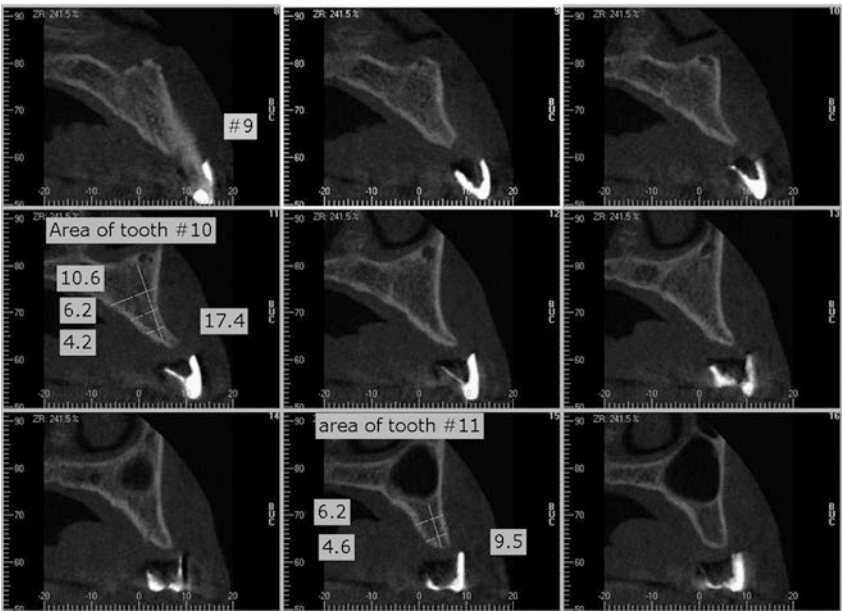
CBCT image of maxillary implant site with radiographic guide
